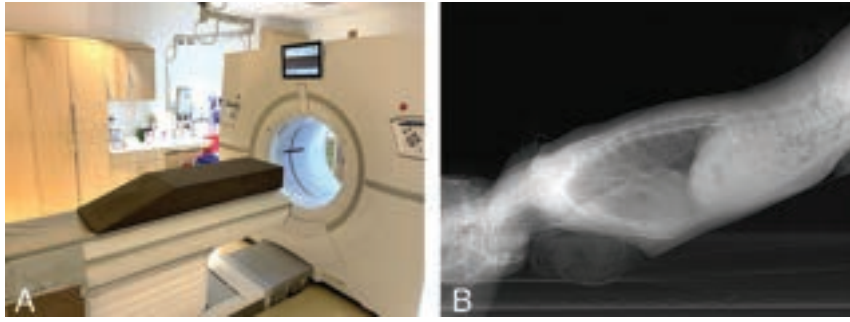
Patient positioning for modified dynamic CTM. *A*, A custom-made firm wedge with a 15° slope is placed on the CT gantry. The hips are placed at the apex of the wedge, with the feet closest to the scanner. The patient is positioned Trendelenburg prone for presumed ventral dural tears (type 1 CSF leaks) and positioned Trendelenburg decubitus for presumed ruptured meningeal diverticula (type 2 CSF leaks). *B*, A lateral scout radiograph shows an adequate angle for contrast to flow from the lumbar puncture site to the cervical spine.
